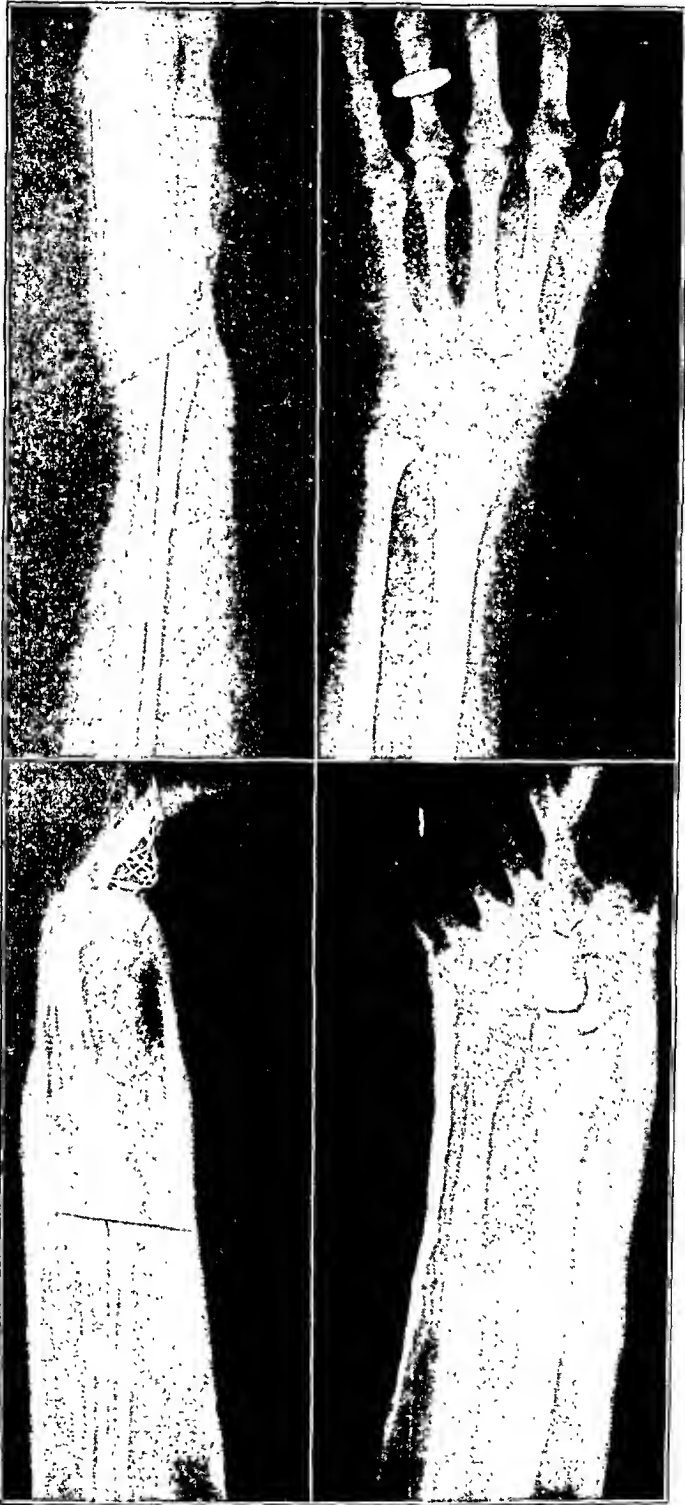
Roentgenograms in a typical case. Above, before reduction; below, after the cast has been applied, showing how straight traction on the thumb only has corrected the deformity and given a reasonable amount of ulnar deviation.
